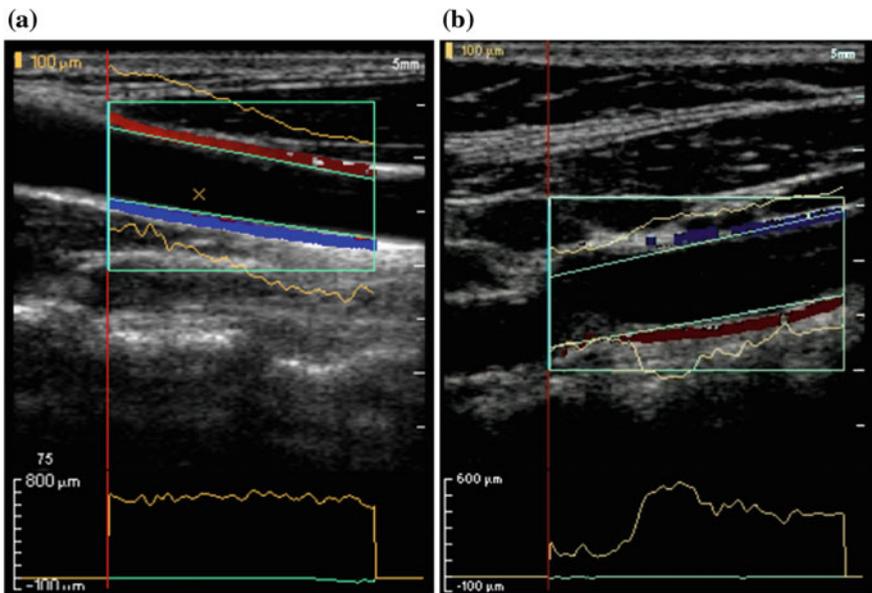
Multi-line wall motion. Top: TDI images and instantaneous wall displacement (magnified). Bottom: maximum wall distension. a Healthy carotid showing no change in maximum distension with position along the vessel axis. b Stenosed artery showing restriction of movement within the region of the stenosis. From; Dineley JA. Doppler ultrasound measurement of arterial wall motion; Ph.D. thesis; Edinburgh: Edinburgh University Library; 2006; reprinted with permission from the author
